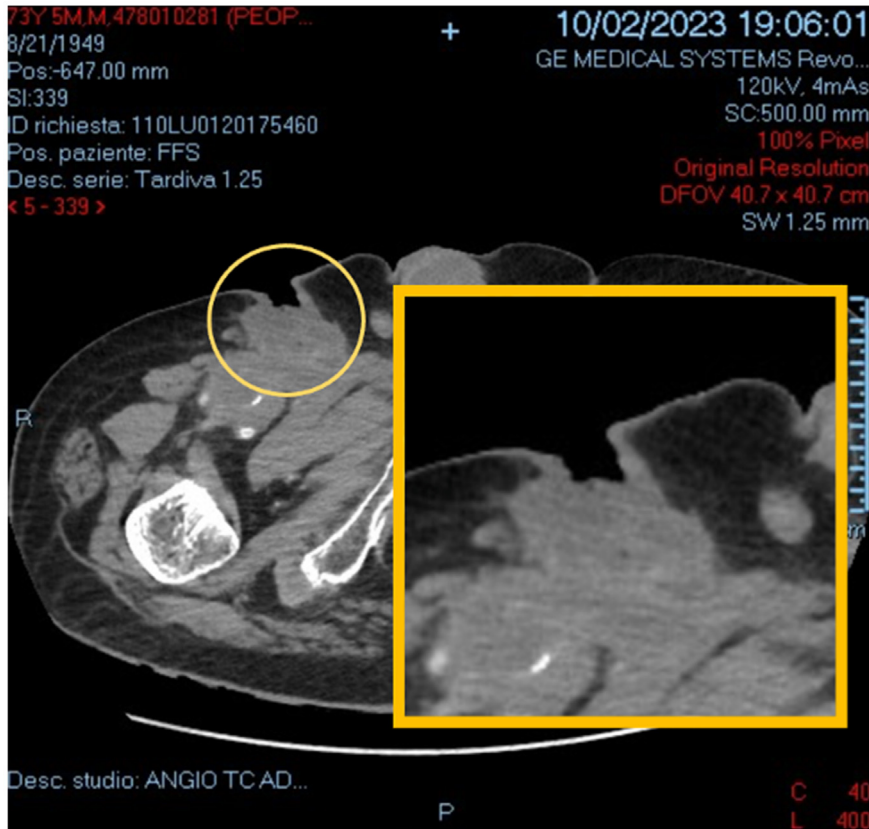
Computed tomography angiography (CTA) showing right groin mass causing fistulization toward the surface.
